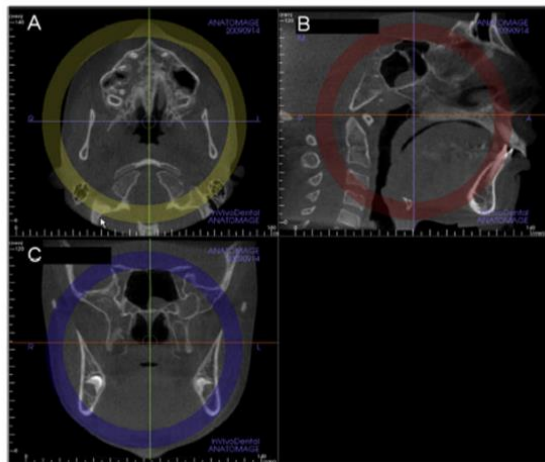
axial A, sagittal B, Coronal C planes in CBCT images
